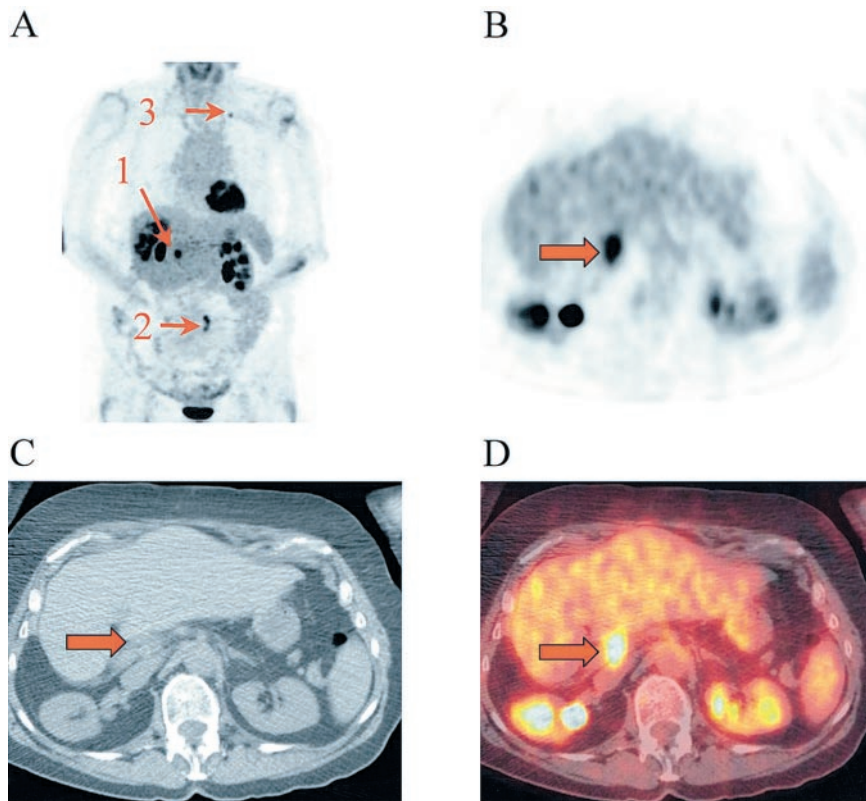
^{18}F -FDG PET images in anterior projection display (A) of patient with foci of increased tracer uptake near inferior border of liver (1), left paraaortic lymph nodes (2), and left upper lung nodule (3). Lung nodule and paraaortic lymph nodes were correctly localized and characterized with PET alone. However, precise location of lesion (1) was difficult to determine, and level 0 was assigned (uncertain; liver or porta hepatis). Transverse PET images (B) at level of lesion (1) clearly showed that activity (arrow) had corresponding lymph node on CT image (C) and fused image (D). Localization was thus improved from uncertain to definite (score 2) with PET/CT.
